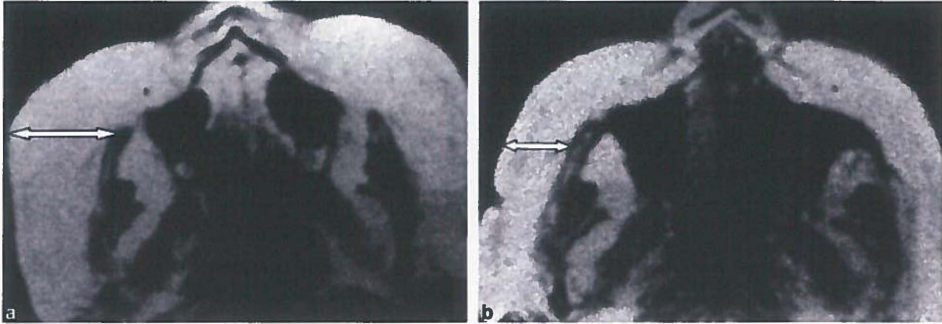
Case 1. (a) Preoperative magnetic resonance scan of the middle third of the face. The soft tissue of both cheeks are diffusely infiltrated with silicone. Arrows show the infiltrated soft tissue. (b) Comparative postoperative scan of the same region after one treatment with ultrasound-assisted liposuction to the cheeks. Arrows show that the thickness of the soft tissues has diminished.
